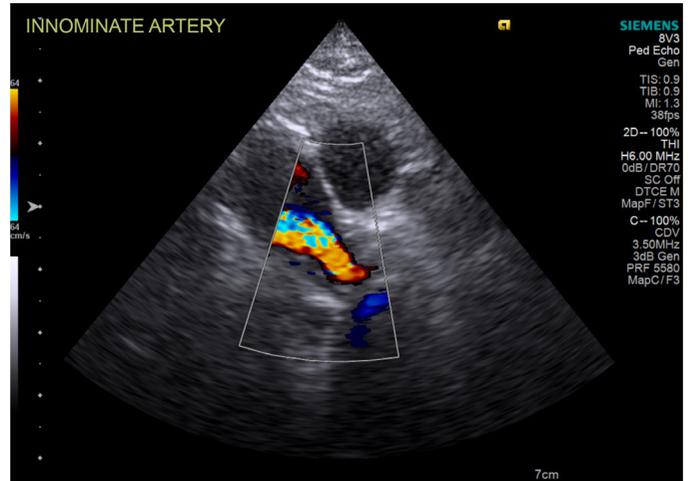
Accelerated flow with aliasing effect in color Doppler mode in the innominate artery
